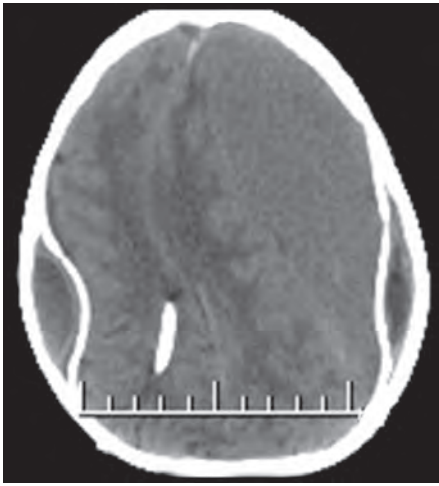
CT scan of the brain showing bilateral extradural haemorrhage and contralateral subdural haematoma following ventriculoperitoneal shunt
